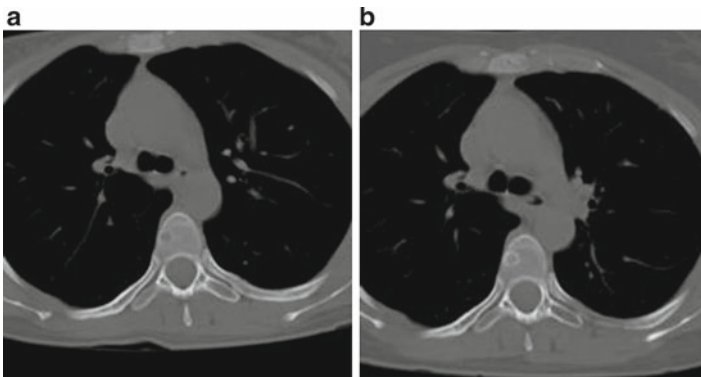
CT of thoracic spine showing a small lytic lesion due to breast cancer metastasis (a) presenting rim sclerosis after response to chemotherapy (b)
